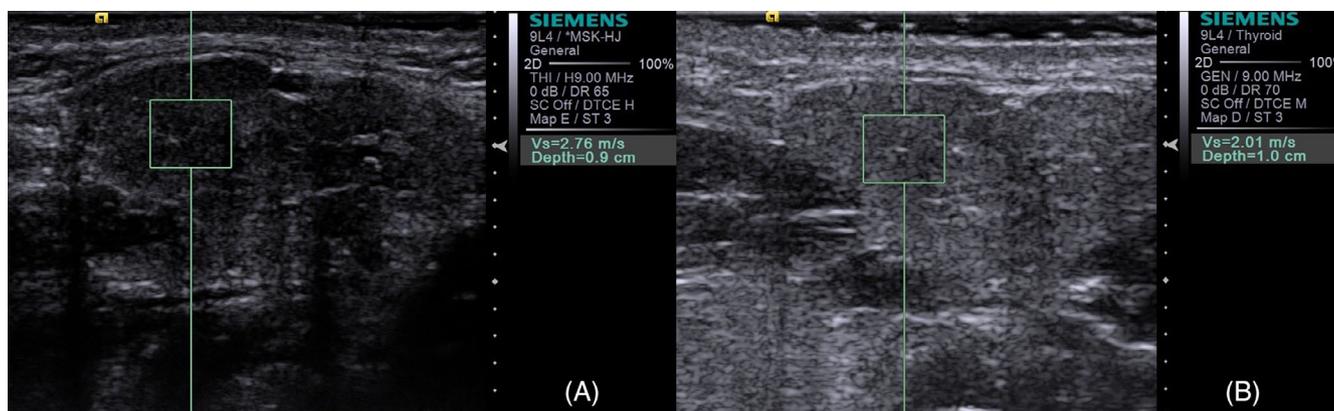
(A) Preoperative ultrasound shear wave elastography. (B) Postoperative ultrasound shear wave elastography
